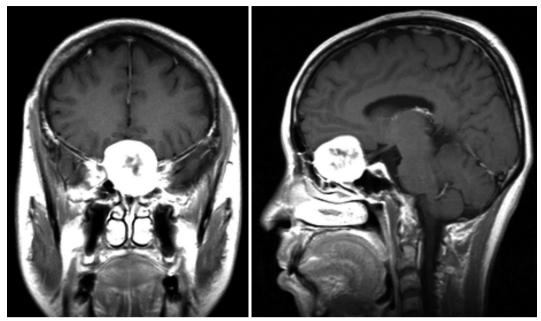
Coronal and sagittal magnetic resonance imaging with gadolinium shows an extra-axial mass at anterior cranial fossa. The tumor extends to the nasal cavity. However, the tumor does not extend to the optic canal. Neither olfactory nerves is identified.
